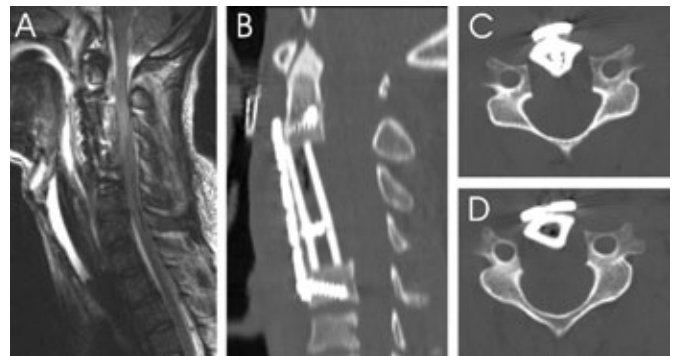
(A) Postoperative magnetic resonance imaging demonstrated complete resection of the tumor and relief of spinal cord compression. (B) Postoperative CT scans demonstrated expansion of the spinal canal and with proper positioning of the instrumentation and allograft. Axial images demonstrated the wide exposure of the spinal canal achieved anteriorly through the corpectomies at C4 (C) and C3 (D) with resection to the level of the pedicles.
